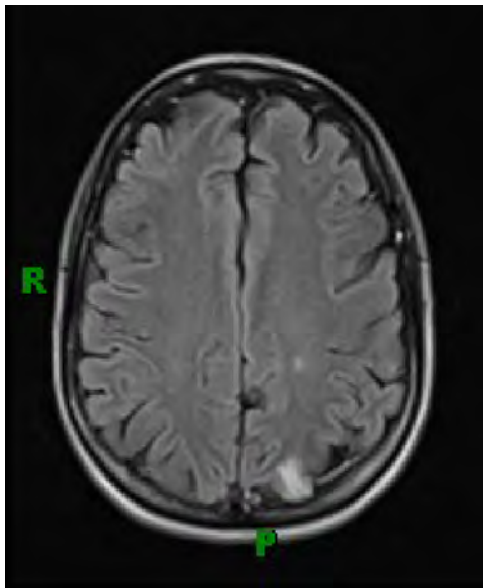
Magnetic resonance image 4 weeks after the discontinuation of gemcitabine and erlotinib shows greatly reduced evidence of lesions.
